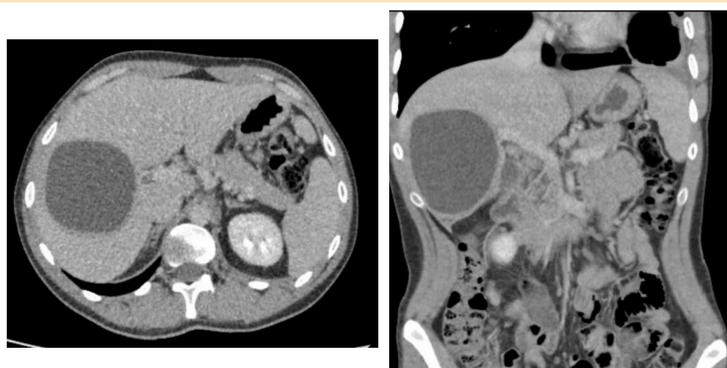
Patients images from CT Abdomen showing a 8.3 x 7.7 x 8.5cm hydatid cyst in the right lobe of the liver
